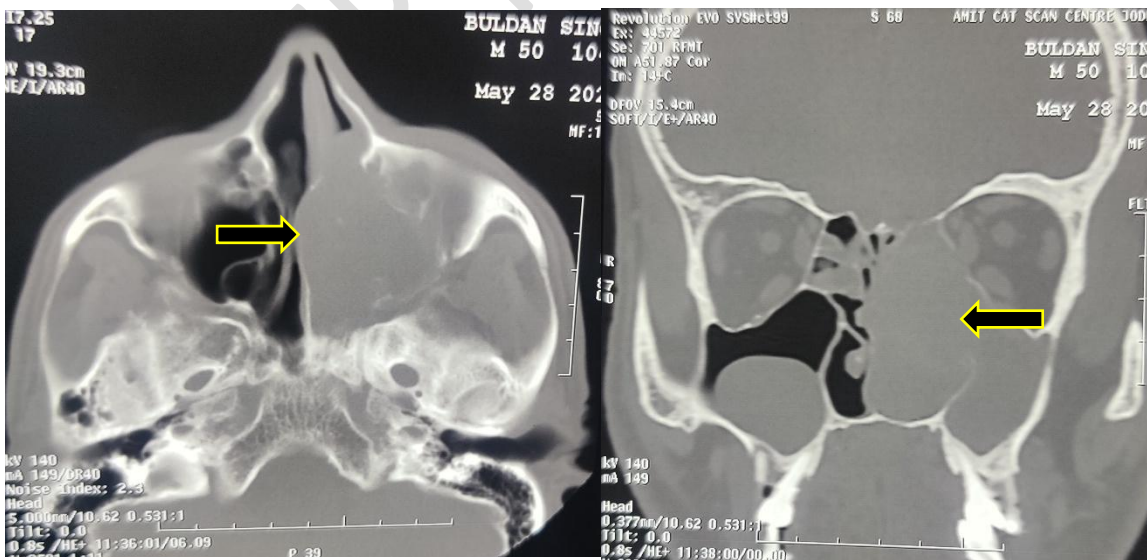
Axial computed tomography scan (Bone window) showing mass occupying the left nasal cavity obliterating the osteomeatal complex without any bone erosion
